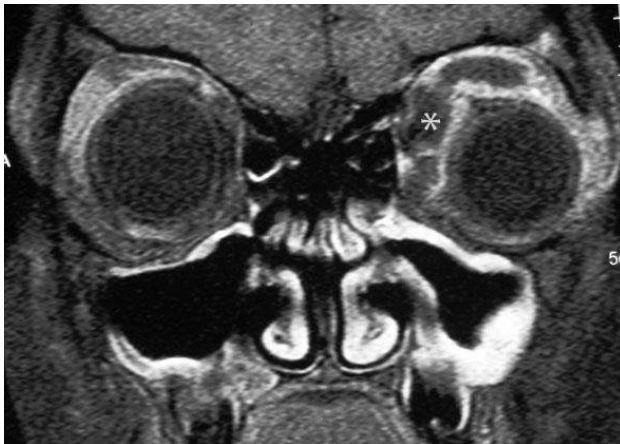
Coronal MRI view of the left extraconal orbital lesion (asterisk) associated with displacement of the orbital globe.
